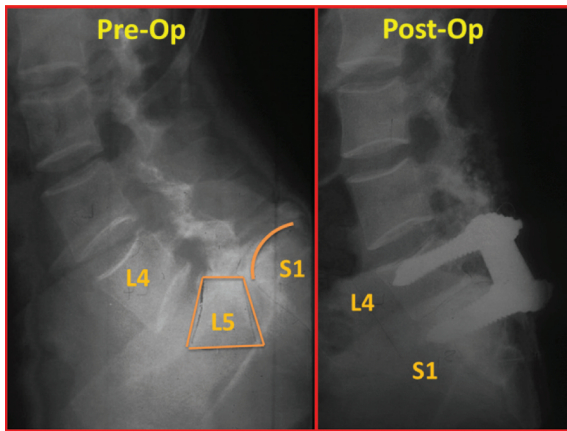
Radiograph after second-stage procedure. L4 was apposed to S1 to achieve “bone-on-bone” apposition.
